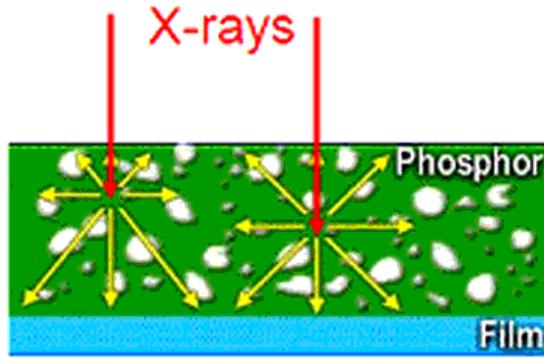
X-rays (red) absorbed by phosphor and converted to visible light (yellow).
